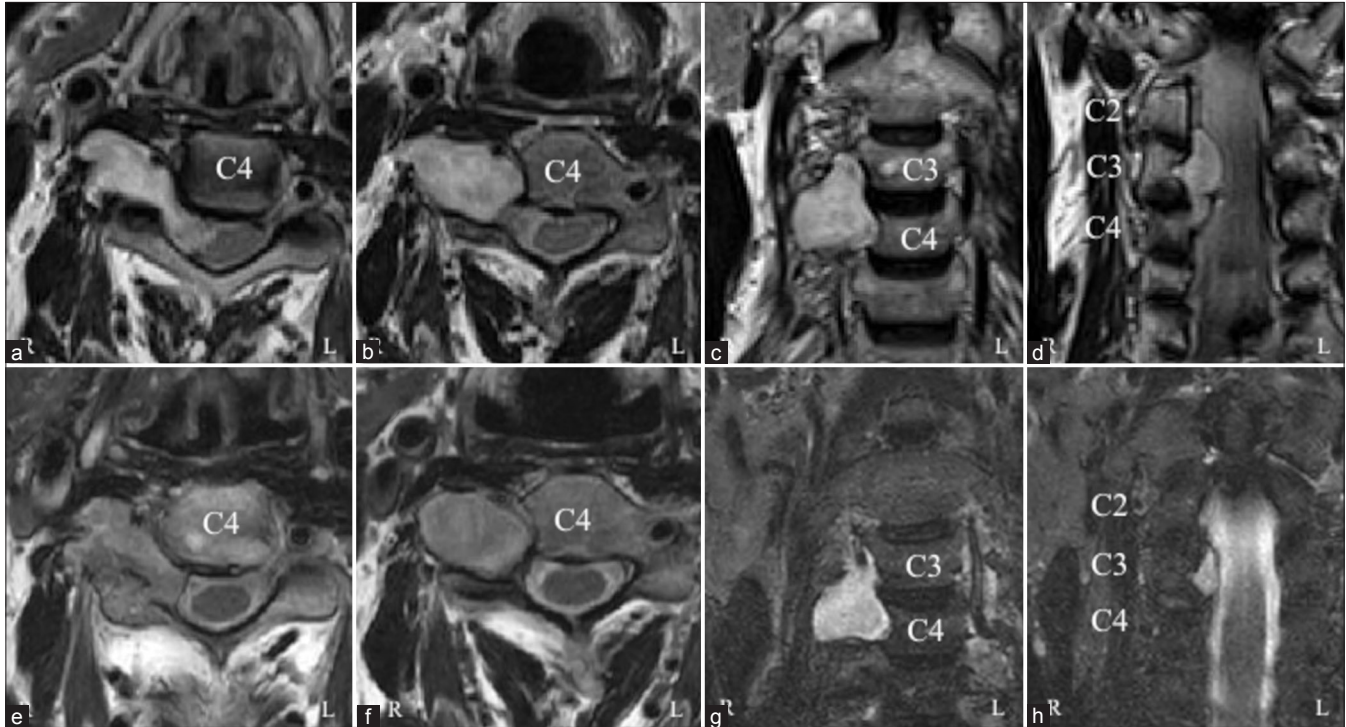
Comparison of initial and follow-up magnetic resonance images. Gadolinium-enhanced, T1-weighted magnetic resonance images reveal spontaneous shrinkage of the cervical dumbbell-type tumor (a-d: Initial images, e-h: Follow-up images, 7 years after the initial examination).
